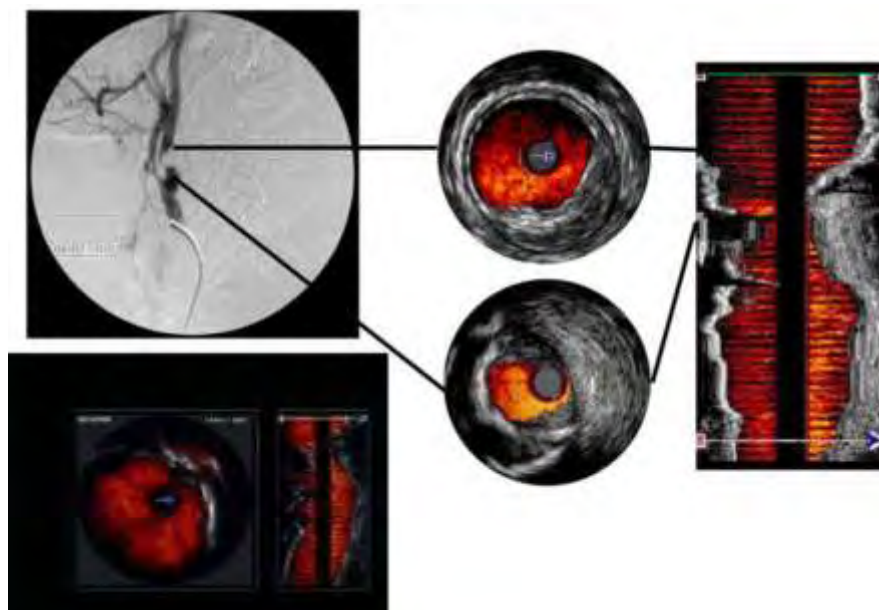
Intravascular ultrasound (IVUS) for imaging of a carotid artery stenosis. IVUS has been occasionally used by some surgeons as the intraoperative completion imaging modality after CEA, but has not been widely adopted, as it is expensive, difficult to use and interpret, and requires arterial puncture. It is more commonly used for evaluation of aortic dissections.
